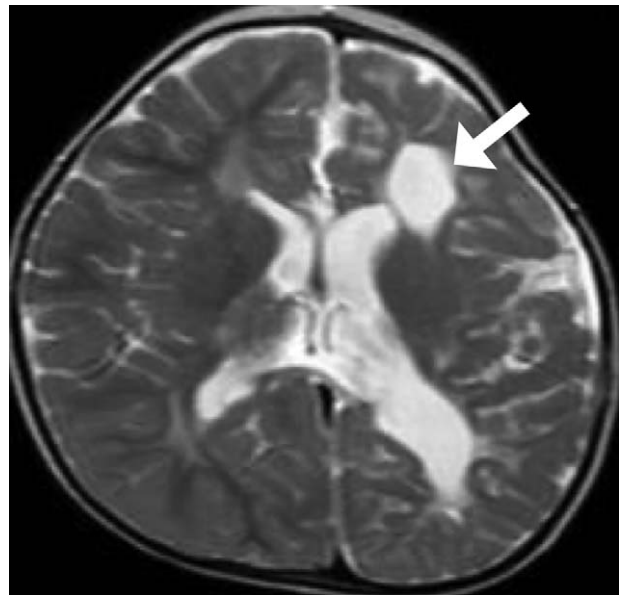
Incontinentia pigmenti. Axial T2-weighted image shows sequelae of parenchymal injury associated with atrophy of the left hemisphere, with compensatory enlargement of the left lateral ventricle, and areas of cystic transformation of the periventricular white matter (white arrow).
